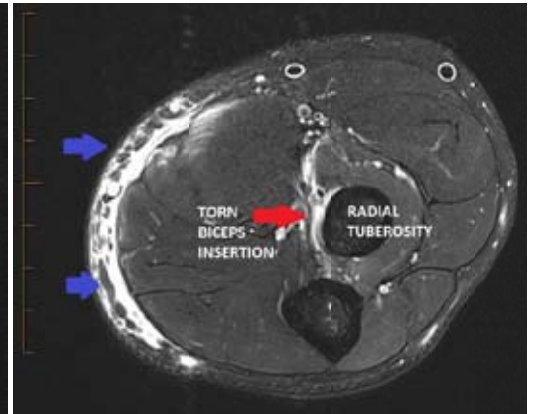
Axial MRI showing rupture of the distal biceps, the tendon is absent from the radial tuberosity (red arrow). The bicipital aponeurosis has also torn causing subcutaneous and deep fascia oedema over the medial forearm (blue arrows).
